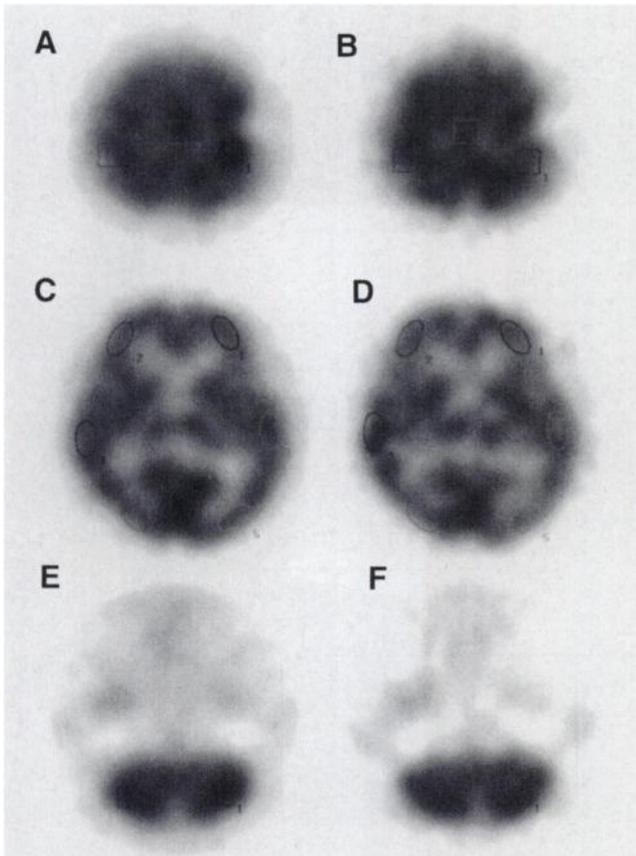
Presentation of ROIs on SPECT. Square ROIs for right and left SMHA and SMA were set on supraventricular-slice SPECT image (A, activation; B, control). Elliptical ROIs for bilateral frontal, temporal, and occipital lobes were set on midthalamic-slice SPECT image (C, activation; D, control). Square ROIs for bilateral cerebellar hemispheres were set on SPECT image of cerebellum (E, activation; F, control).
